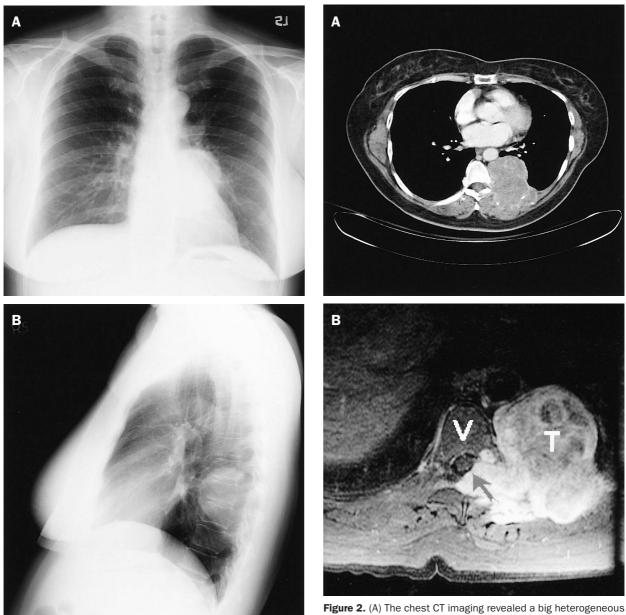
The chest radiographs revealed a sharply marginated round mass over the left lower chest field. (A) PA view. (B) Lateral view.
